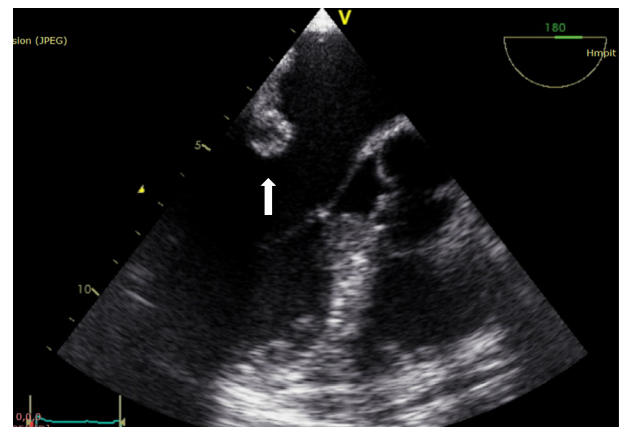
Transesophageal echocardiography showing a rounded, calcified mass with interior content of lower echogenicity.
